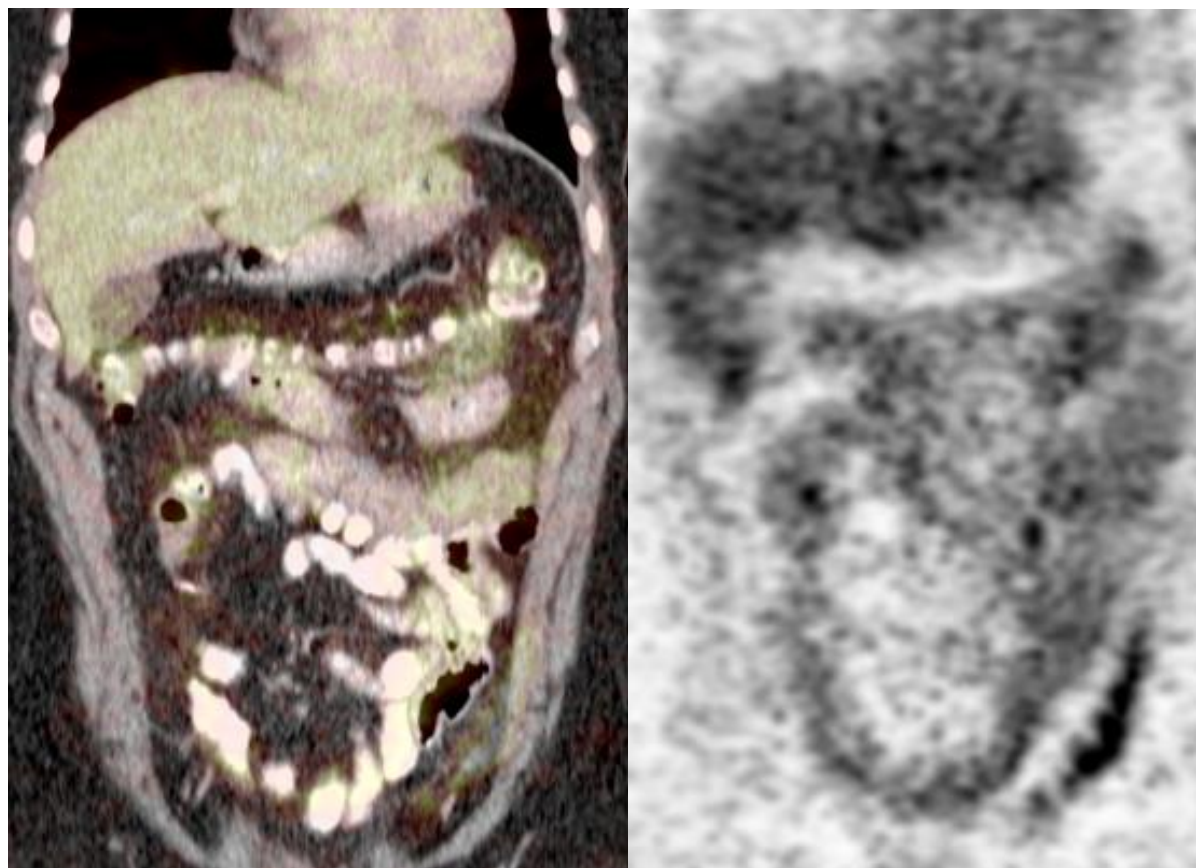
PET CT coronal image. No evidence of abnormal FDG activity
